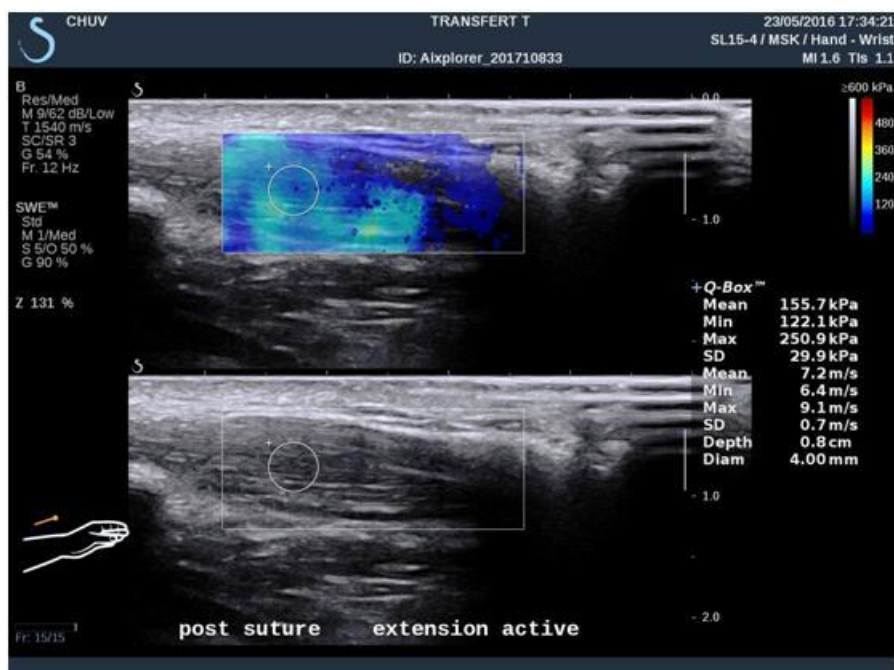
B-mode ultrasound (low) and elastographic (high) recording during the 6th stage of the transfer (TAE).
